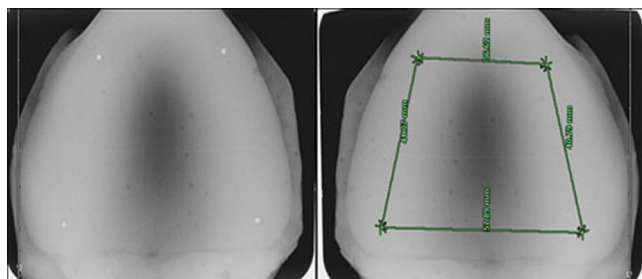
The radiographic image of the metal balls and reference lines on the stone model
